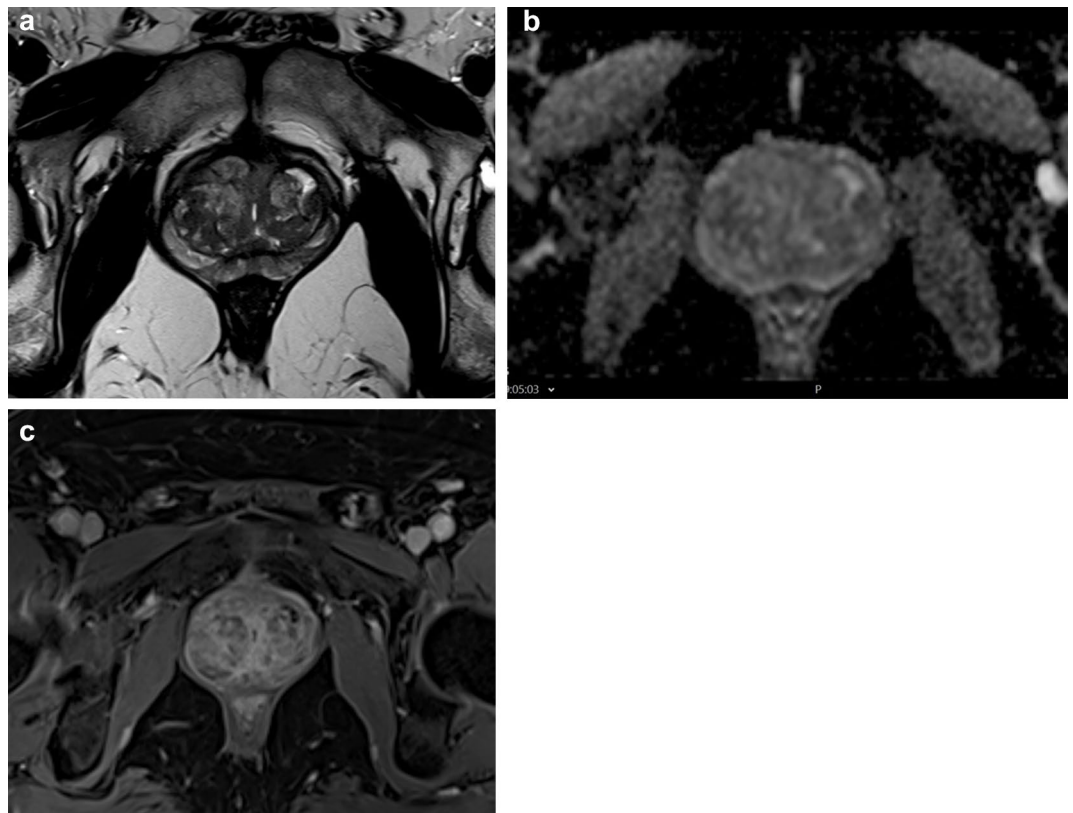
A 70-year-old man who underwent multi-parametric prostate MRI at 3 T. (a) On the axial T2-weighted image, the signal-to-noise ratio is adequate, allowing clear delineation of anatomical structures. No artifacts are present, and the signal-to-noise ratio remains sufficient on both coronal and sagittal T2 W images (not shown). (b) The anatomically matched axial apparent diffusion coefficient (ADC) map is artifact-free, with adequate contrast and signal-to-noise ratio, clearly delineating the peripheral and transitional zones. (c) The vessels are clearly delineated, with no visible artifacts on the dynamic-contrast-enhanced image. All readers assigned a PI-QUAL score of 5 for PI-QUAL V1 and a score of 3 for PI-QUAL V2 in this case.
